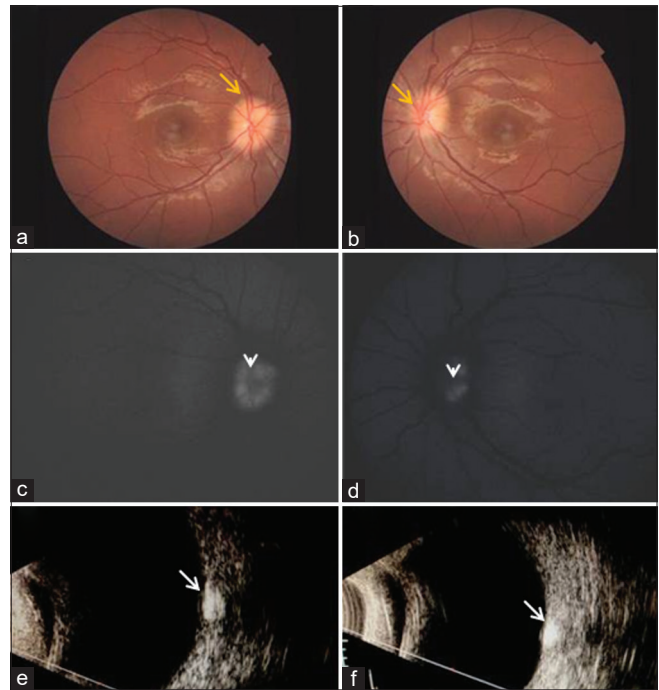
a-b: Fundus photo shows blurred optic disc margins in right and left eye respectively (yellow arrows). c-d: Fundus autofluorescence shows hyper autofluorescence at both optic discs (white arrowheads). e-f: Ultrasound B scan shows hyper-echogenicity at both optic discs. (white arrows)
